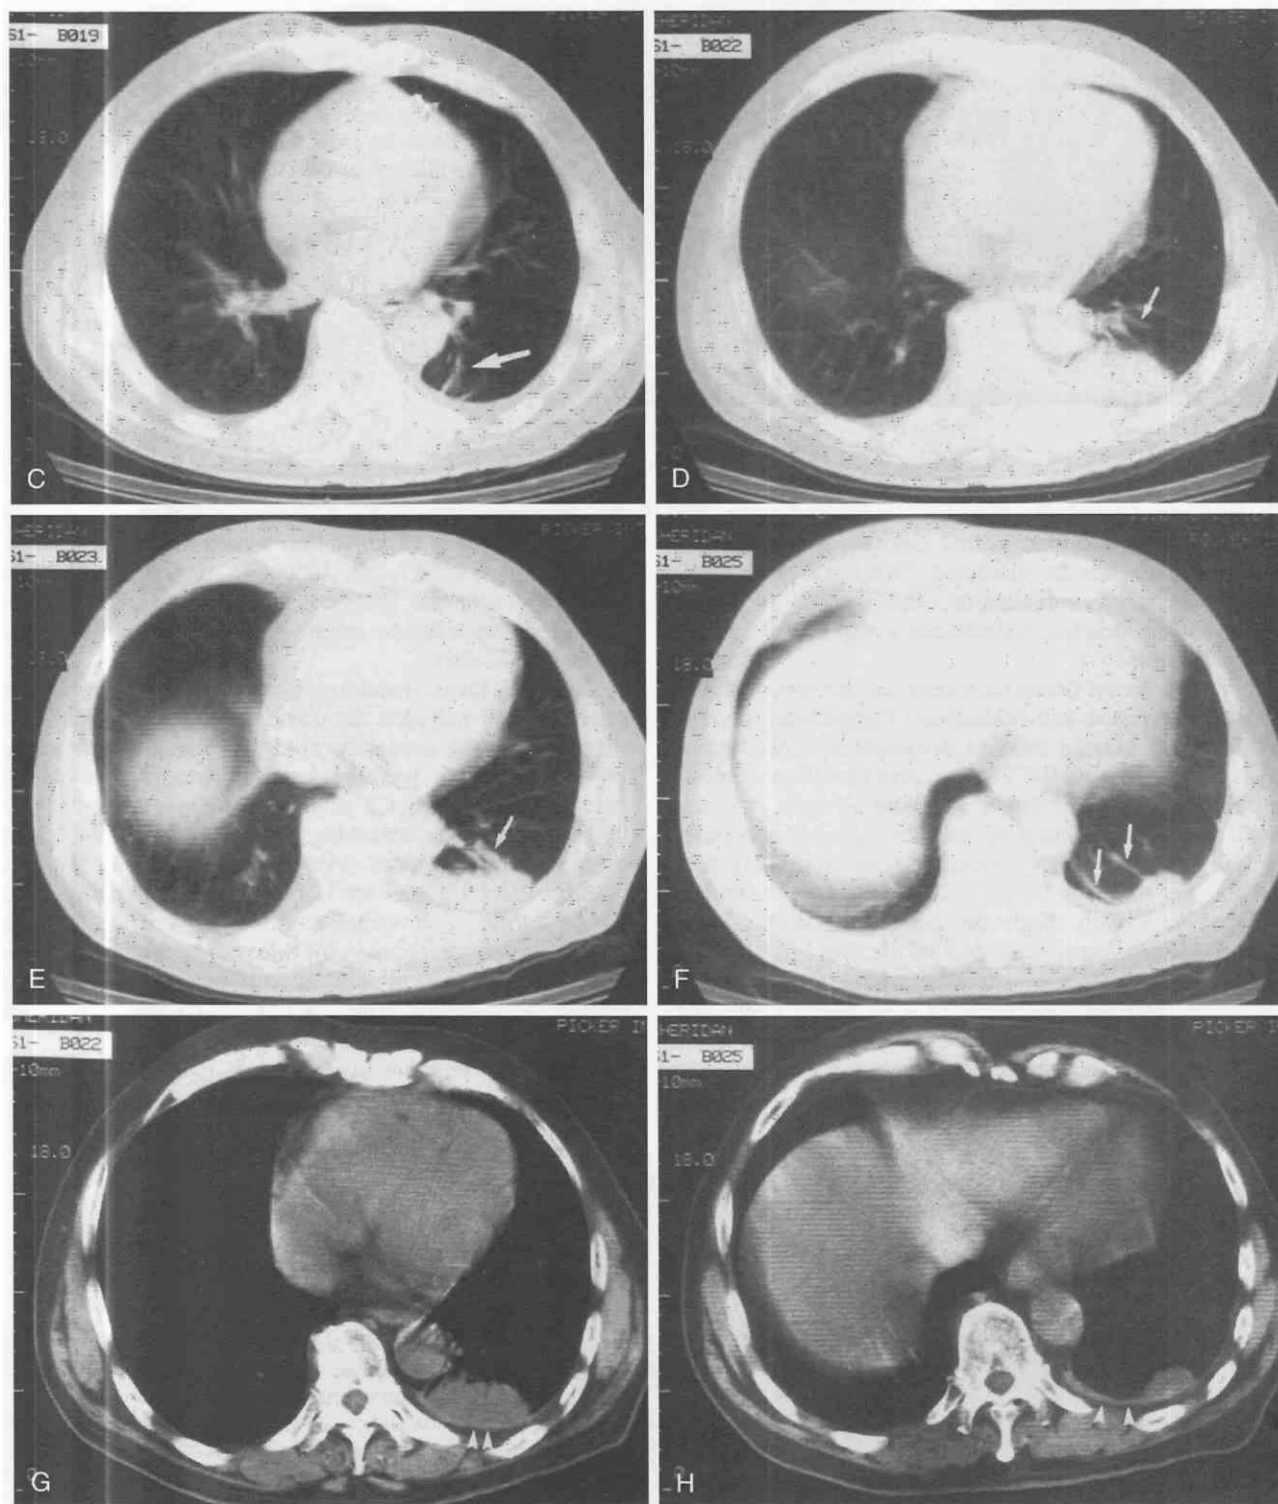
Continued. C-H, Typical features of round atelectasis are visualized by CT. A rounded pleura-based mass is present, with adjacent pleural thickening (arrowheads). Vessels and lung markings curl into the lesion, producing the comet's tail or vacuum cleaner sign (arrows). The predisposing cause in this patient was not asbestos exposure but previous thoracic surgery.
